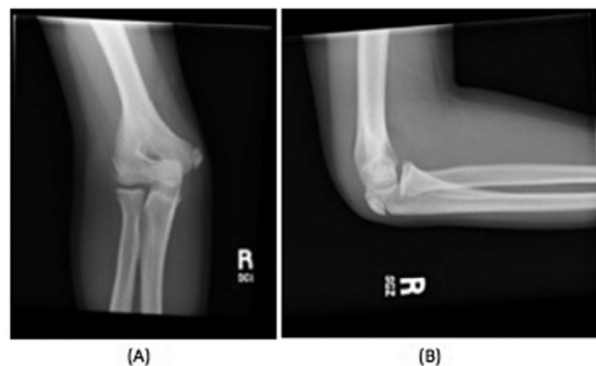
(A) Anteroposterior and (B) lateral plain radiographic views of the right elbow of patient 1 at the time of injury demonstrate a radial head fracture and a small shear fracture off of the capitellum.
